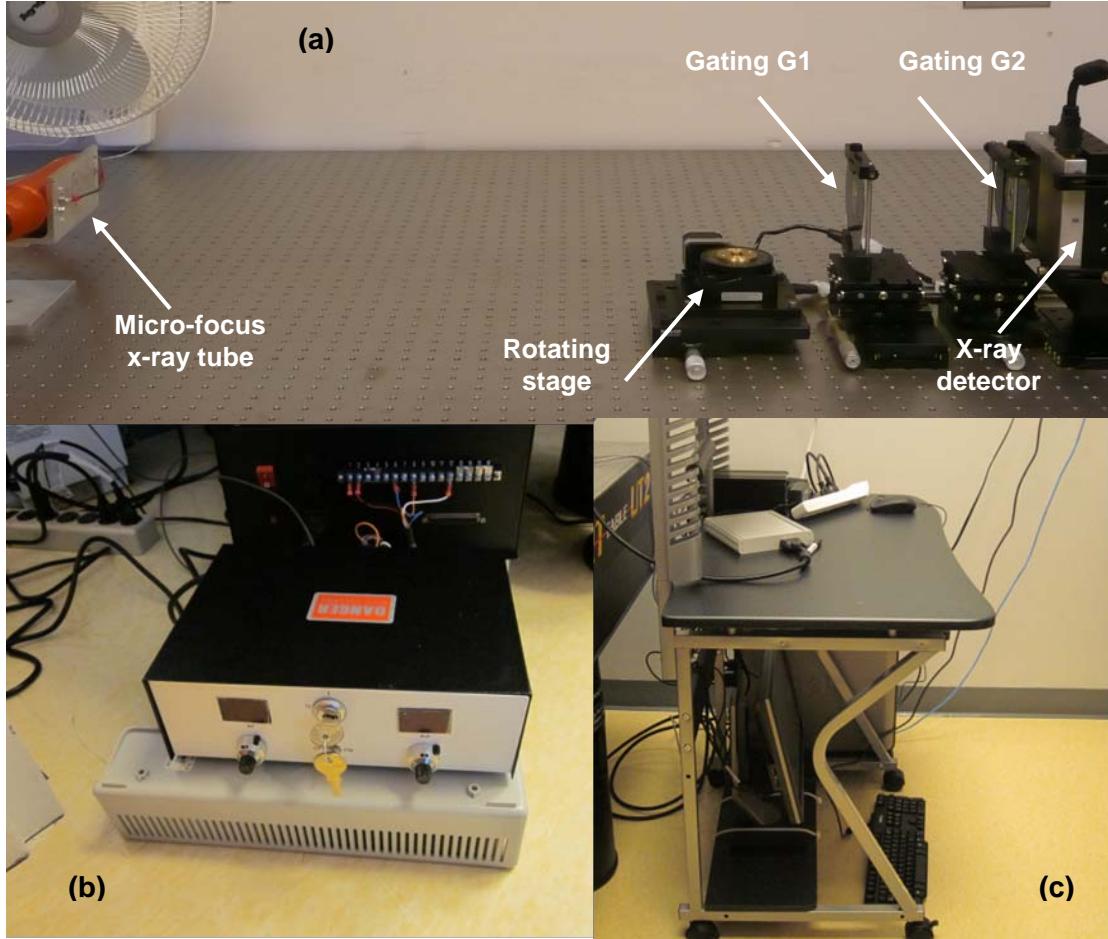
Pictures showing the prototype x-ray phase contrast CT: (a) deployment of x-ray tube, rotation stage, x-ray detector and gratings on the optical table, (b) x-ray generator and (c) system controller.
